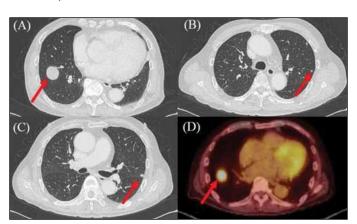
Computed tomography of the lung before chemotherapy. A: Maximum dimensions of mass lesion in the right lower lung. B and C: Two metastases of the left lung. D: 2-18Fluorodeoxy-D-glucose positron emission tomography (FDG-PET) of the lung corresponding to the maximum dimensions of the mass lesion in the right lower lung.
